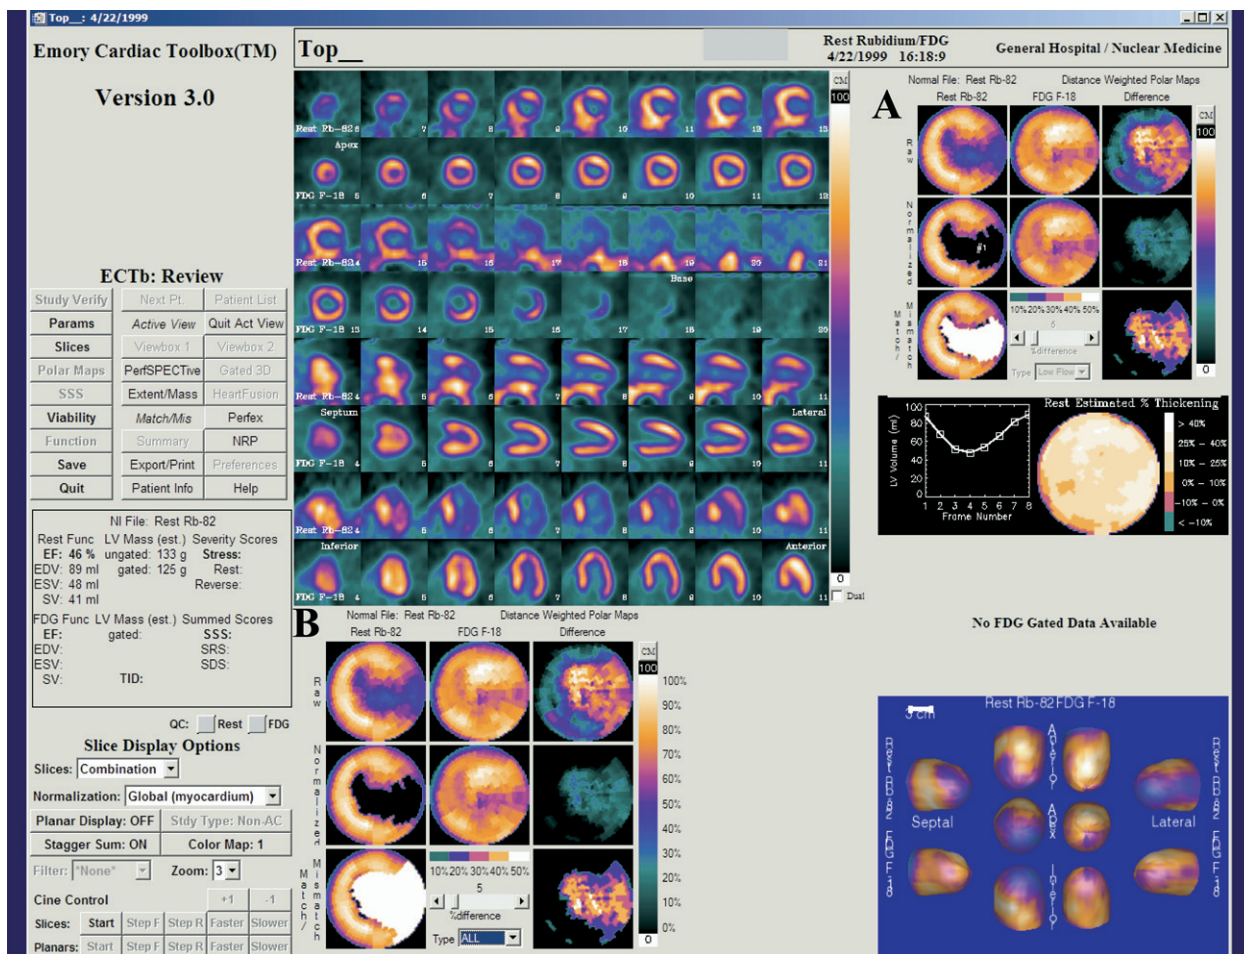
Quantitative perfusion/metabolism match/mismatch results. The oblique slices in this patient depict a resting Rb-82 perfusion distribution with a hypoperfused lateral wall (*alternating top rows*) with a normal FDG metabolic distribution (*alternating bottom rows*). A (*top right*) shows how the resting hypoperfused region highlighted in black improves significantly (*filled in white*) by more than 5% by use of the low-flow approach, where only the hypoperfused region is considered. B shows results via the all-flow approach, the algorithm where all regions that improve by 5% are considered regardless of whether they were found to be quantitatively hypoperfused.
